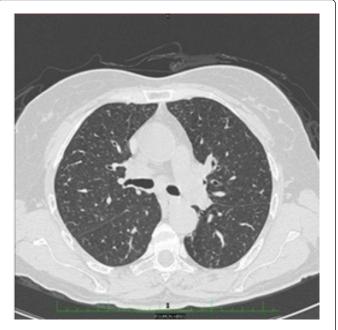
Chest CT scan shows bilateral micronodules, with blurred margins, that predominate in the two upper lobes.
